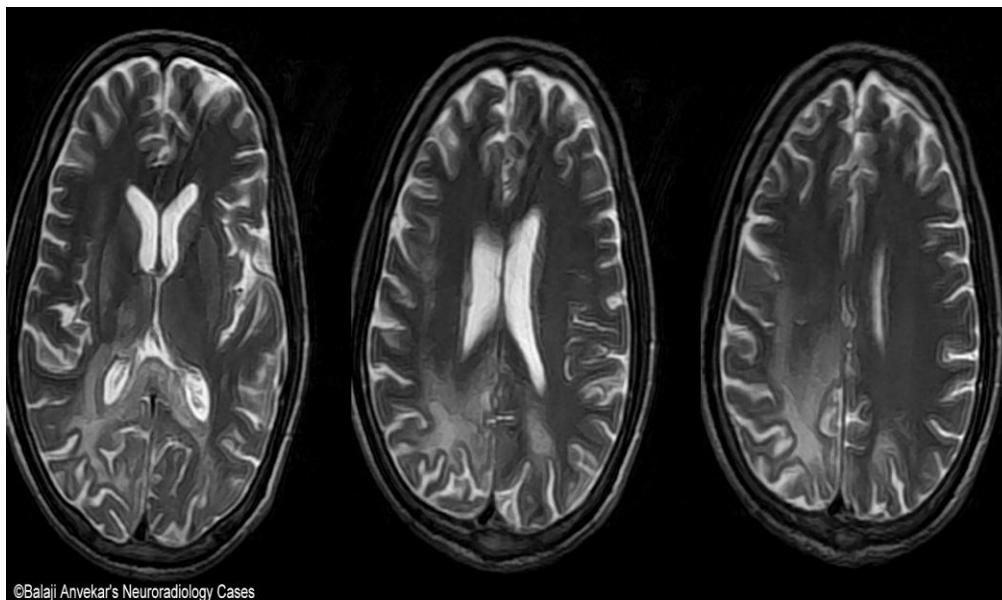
MRI study of Brain shows: Bilateral patchy ill defined parietal T2 hyper intensities confined to white matter, peri ventricular as well as sub cortical for encephalitis patients
